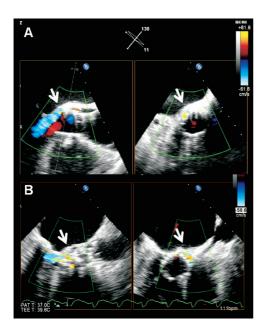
Current 3-D transoesophageal probes permit simultaneous visualisation of the transcatheter aortic valve in orthogonal (long- and short-axis) views to exactly localise the paravalvular leak. The arrows indicate that the paravalvular leak is located at the posterior part of the aortic annulus, close to the anterior mitral valve leaflet. The paravalvular leak is mild in severity as it occupies <10% of the circumference of the prosthetic valve (A) and is moderate in severity as it occupies 10-20% of the circumference of the prosthetic valve (B).
